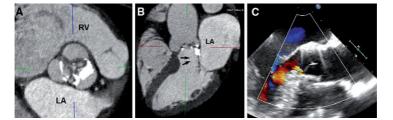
Aortic valve calcification assessed using multidetector row computed tomography (*MDCT*): implications for transcatheter aortic valve implantation. a shows a calcified tricuspid aortic valve with bulky calcification mainly in the *left* cusp, *left-right* commissure and extending to the base of the anterior mitral valve leaflet (indicated by *arrows* in b). Following TAVI, paravalvular leak was observed with colour Doppler transesophageal echocardiography in the long-axis view
